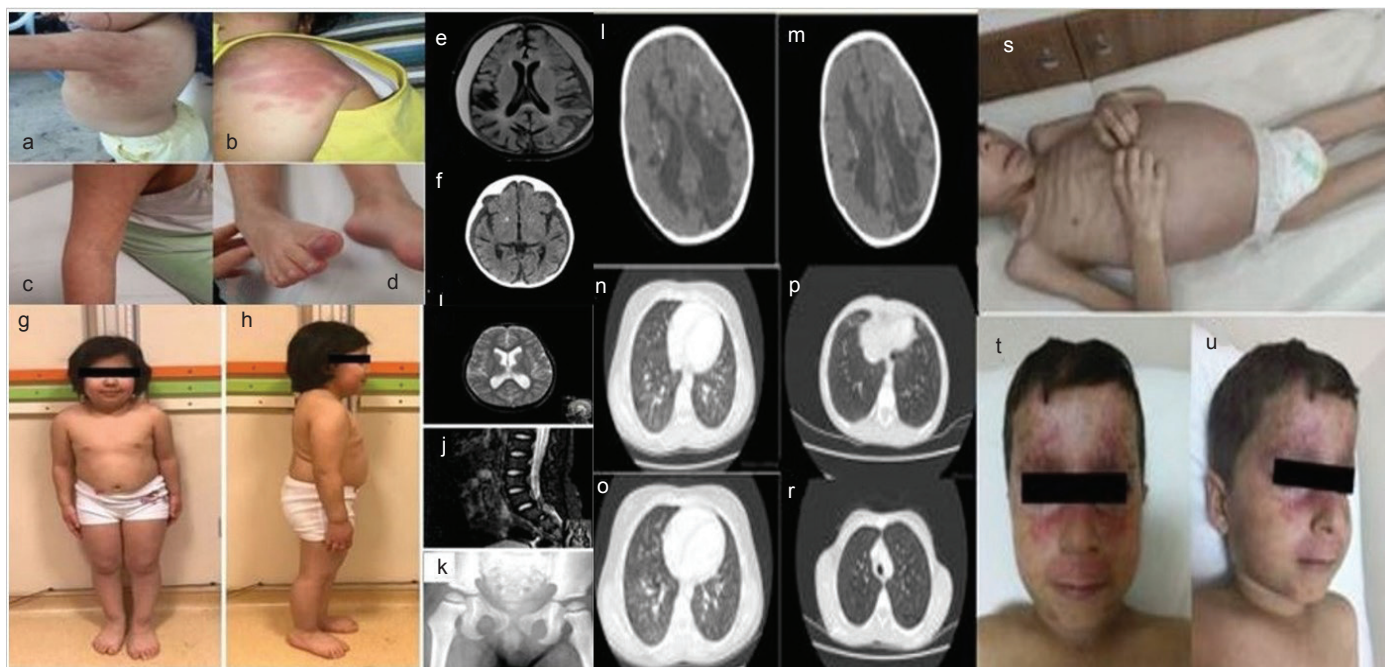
Clinical and screening findings of our patients with type I interferonopathies. 8 years old girl with familial systemic lupus erythematosus (FSLE) (*homozygote C1Q* gene mutation): (a, b) Skin rash, (c) Livedoid rash, (d) Chilblain lesions on digital tips, (e) Subdural hematoma and cerebral atrophy, (f) Intracranial calcifications in magnetic resonance imaging (MRI). 4 years old girl with Spondyloenchondrodysplasia (*homozygote ACP5* gene mutation): (g, h) short stature, (i) mild ventricular dilatation and cortical atrophy in MRI, (j) platyspondyly of the lumbar vertebrae in MRI, (k) metaphyseal hyperintensity of proximal femur in X-ray. 3 years old girl with Aicardi Goutières Syndrome (*homozygote SAMHD1* gene mutation): (l, m) intracranial calcifications and ventricular dilatation in MRI. 11 years old girl with STING-associated vasculopathy with onset in infancy (*homozygote TMEM173* gene mutation): (n, o) bilateral ground glass opacity in chest computed tomography (CT). 4 years old girl with COPA syndrome (*homozygote COPA* gene mutation): (p, r) diffuse sub centimetric cyst and local honeycomb appearance accompanied by fibrotic changes in chest CT. 7 years old boy with Aicardi-Goutières Syndrome (*homozygote IFIH1* gene mutation): (s) abdominal distention and lipodystrophy. 4 years old boy with FSLE (Homozygote C1Q gene mutation): (t, u) malar rash.
